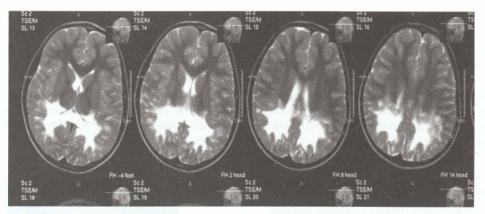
Brain MRI findings in X-linked adrenoleukodystrophy. T2 weighted axial images show symmetrical hyperintense signal changes in the bilateral parieto-occipital white matter and splenium of corpus callosum (*Courtesy:* Dr. Atin Kumar, Deptt. of Radiodiagnosis, AlIMS, New Delhi)
